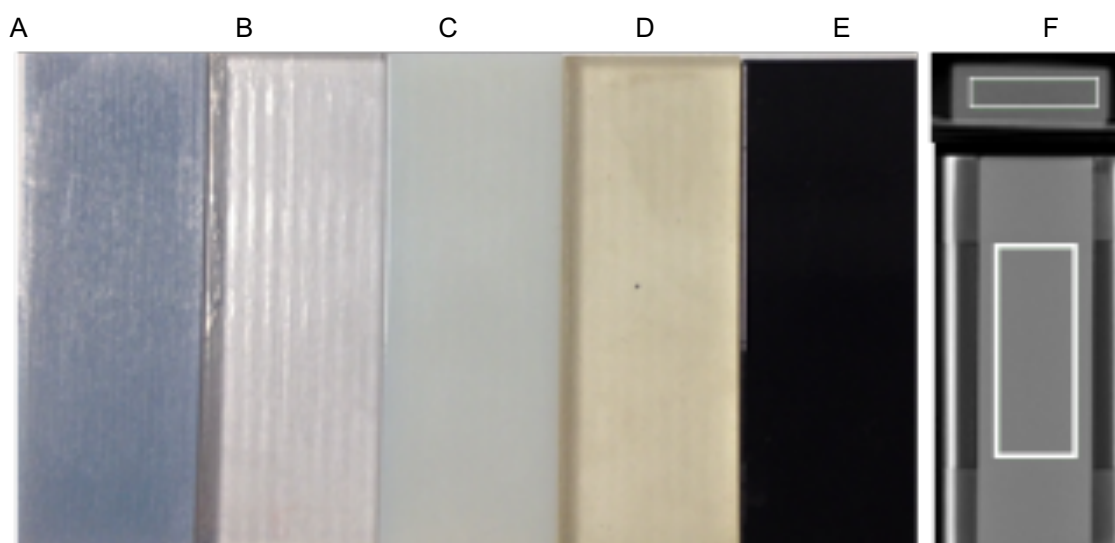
Photographs of selected 3D-printing materials used in this study. (A) Vero Blue (B) Perspex, (C) Vero Clear, (D) Vero White and (E) Tango Black. From A to E there is a change in material density. Panel (F) is a representative image (axial and coronal planes in display) showing VOI placement on the CT acquisition for each material for HU measurements (F).
